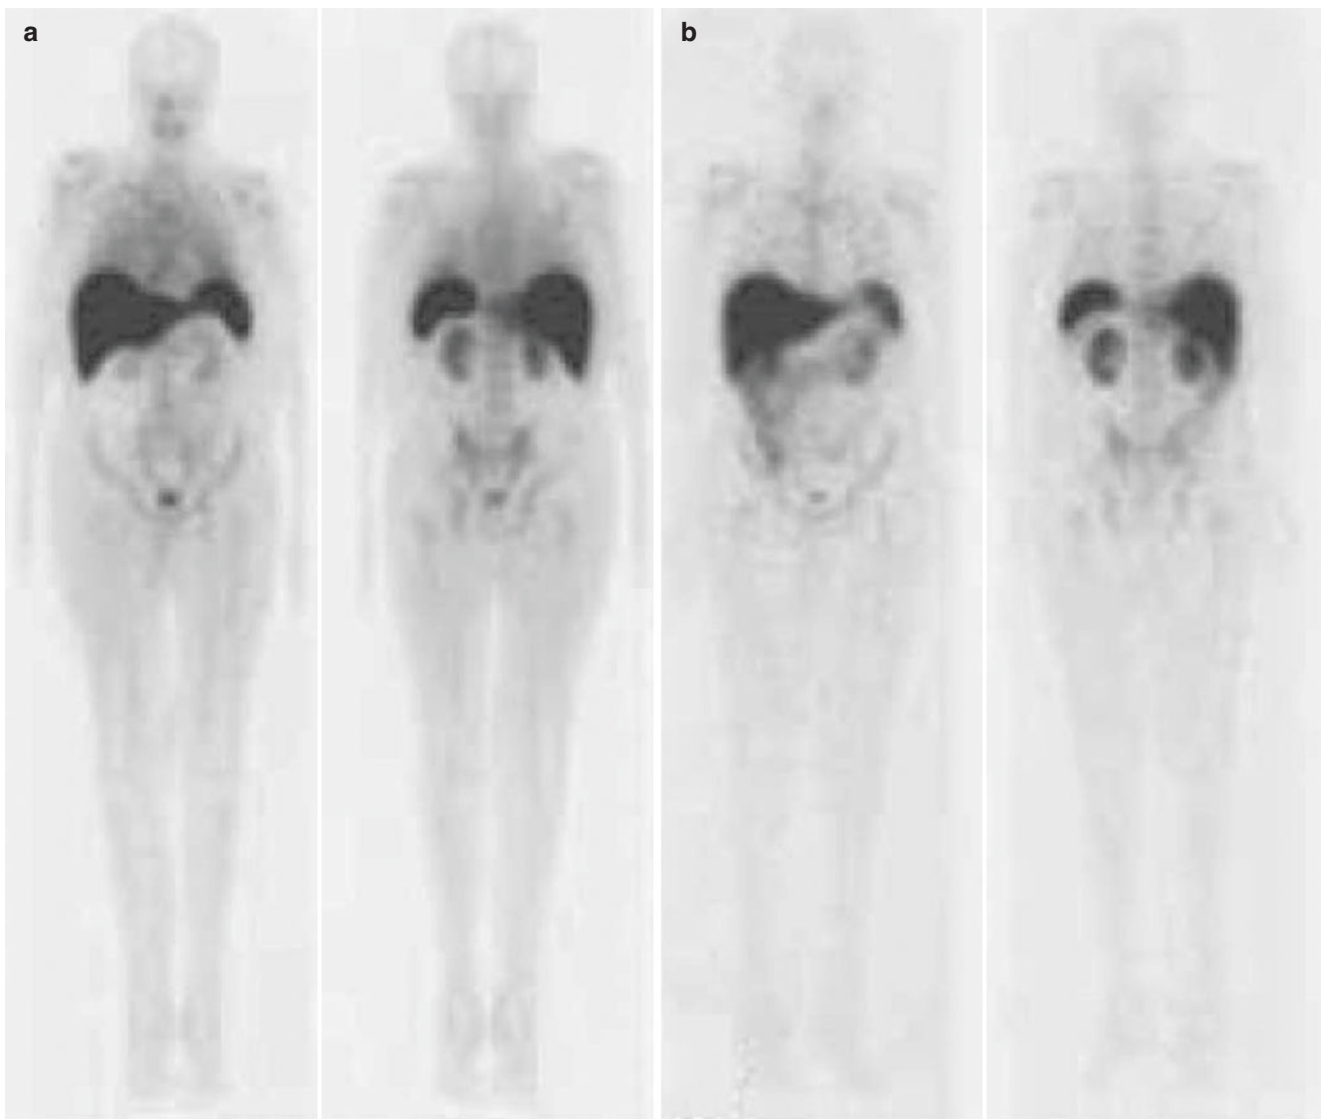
^{99m}Tc -Scintimun scintigraphy: anterior and posterior whole body images obtained 30 min (a) and about 3 h (b) post-injection, showing physiologic distribution of the radiopharmaceutical with uptake in the bone marrow, spleen, and liver; residual blood pool activity can also be seen
